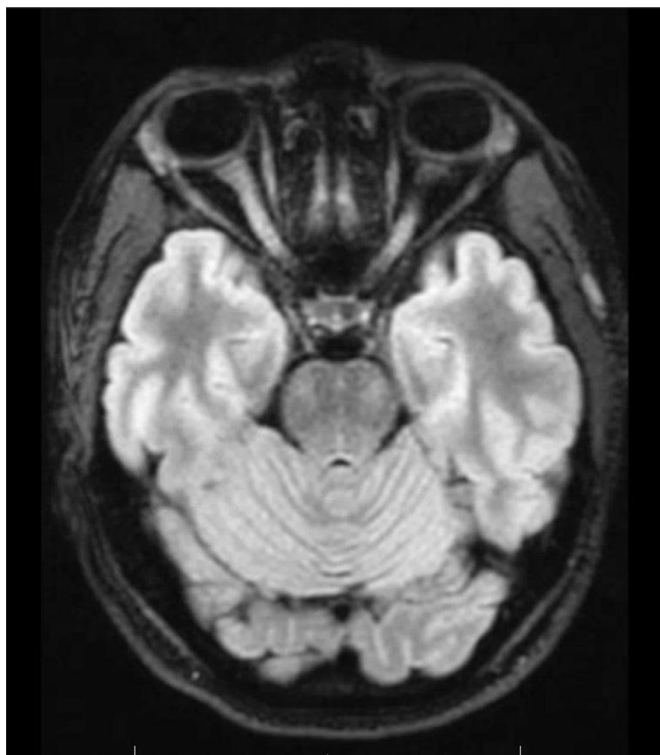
T2 weighted axial MRI without contrast, demonstrating mildly increased T2 signal intensity within the bilateral optic nerves.
